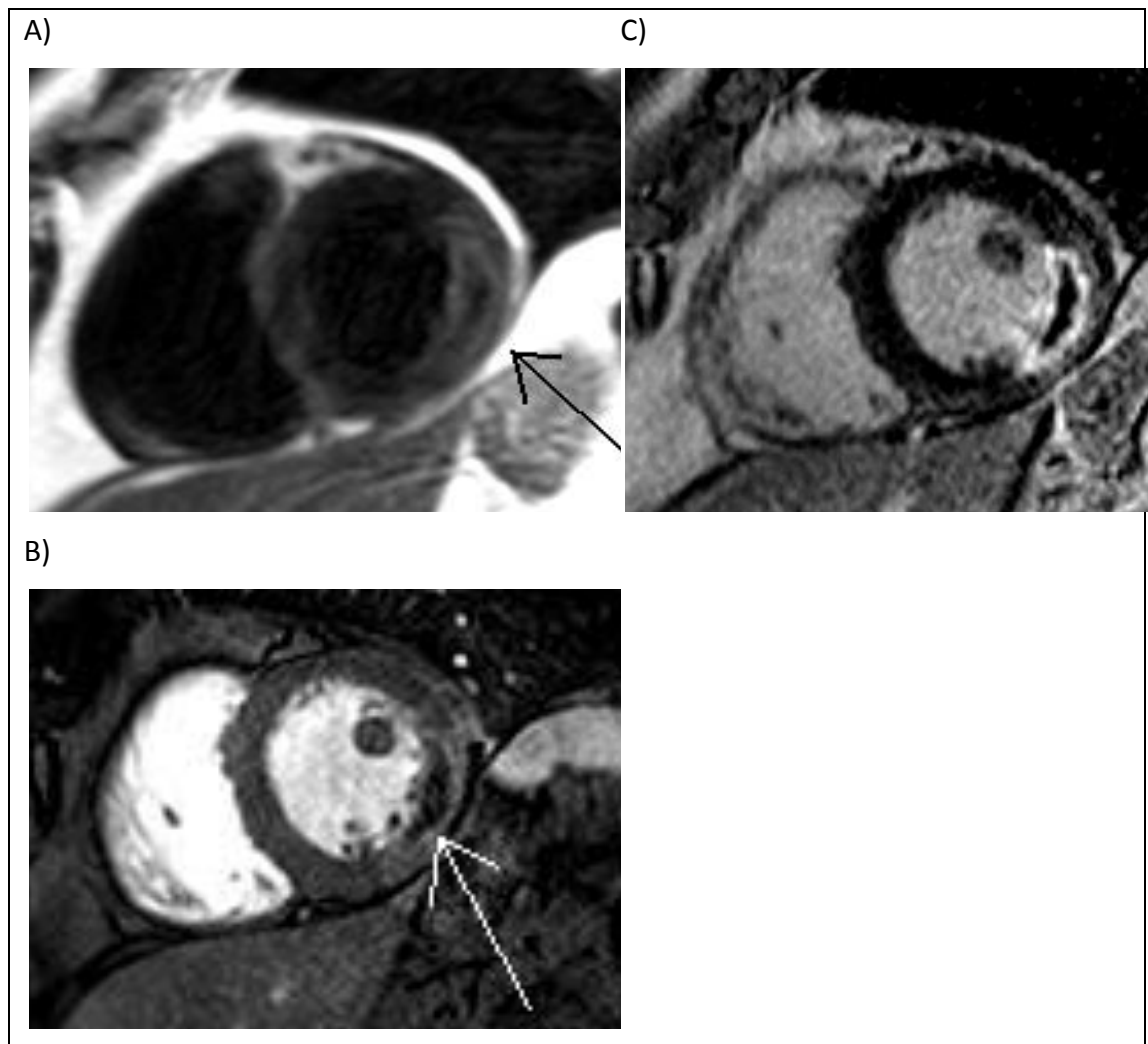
CMR images taken at 36 hours from a study patient presenting with a lateral STEMI due to an occluded left umflex coronary artery. A) T2-weighted scans showing increased tissue oedema in the lateral wall, B) Gd-enhanced perfusion images demonstrating dark areas at the endocardial border representing microvascular obstruction (MVO), and, C) T1-weighted images demonstrating areas of late gadolinium enhancement representing early infarct size with a dark core of MVO that corresponds to the early perfusion images
